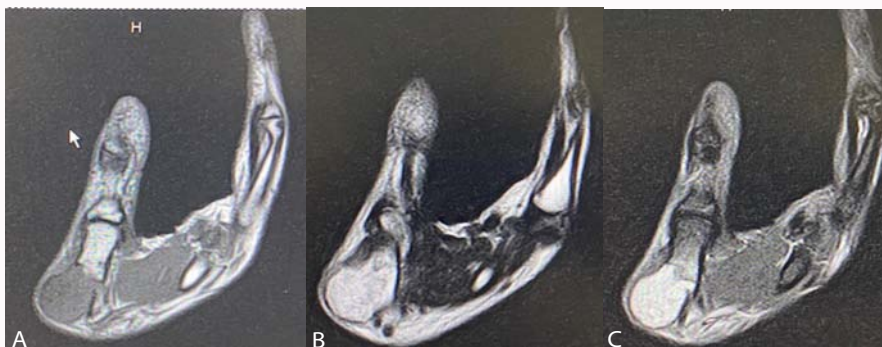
MRI. A: Hypointense and homogeneous T1 image. B: Hyperintense and partially heterogeneous T2 image. C: Hyperintense and homogeneous STIR image.
